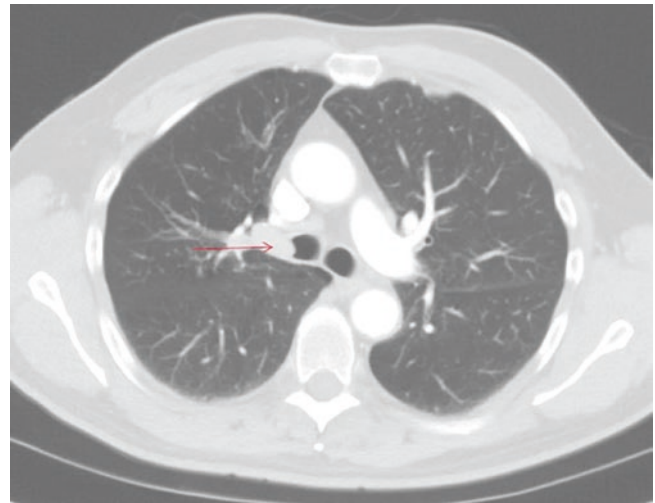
61-year-old male with large-volume hemoptysis and respiratory distress. Computed tomography of the chest showed a well-circumscribed 2.5 cm nodule in the right upper lobe bronchus extending into the right mainstem (arrow). A rigid bronchoscopy was performed to debulk and cauterize the tumor. Two months later, he underwent a video-assisted thoracoscopic lobectomy for a pT1bN0M0 squamous cell carcinoma of the right upper lobe
